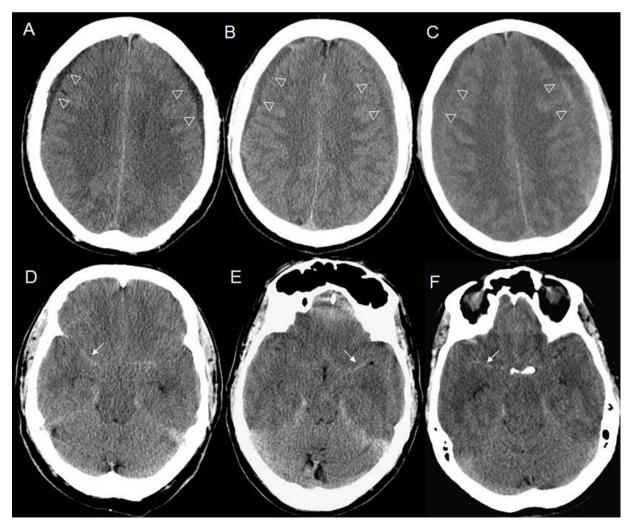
Nonenhanced CT scans pt. 1 (A and C), pt. 5 (B and E), pt. 6 (C and F). Subdural hematomas (SH) (A–C arrowheads) without mass effect (A and D), SH with minimal mass effect (B and E), SH with significant mass effect (C and F). Notice increased attenuation in the basilar cisterns/sylvian fissures (i.e., pseudo-subarachnoid hemorrhage) (D–F white arrows) and tentorium (D–F).
